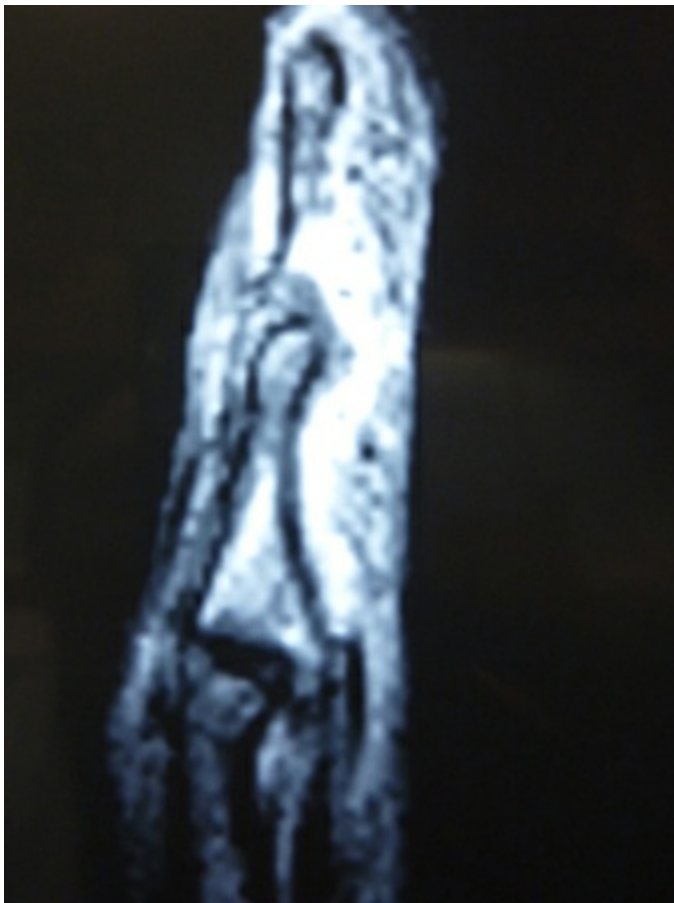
Sagittal MRI shows retraction of a closed FDP rupture to the proximal phalanx level.
